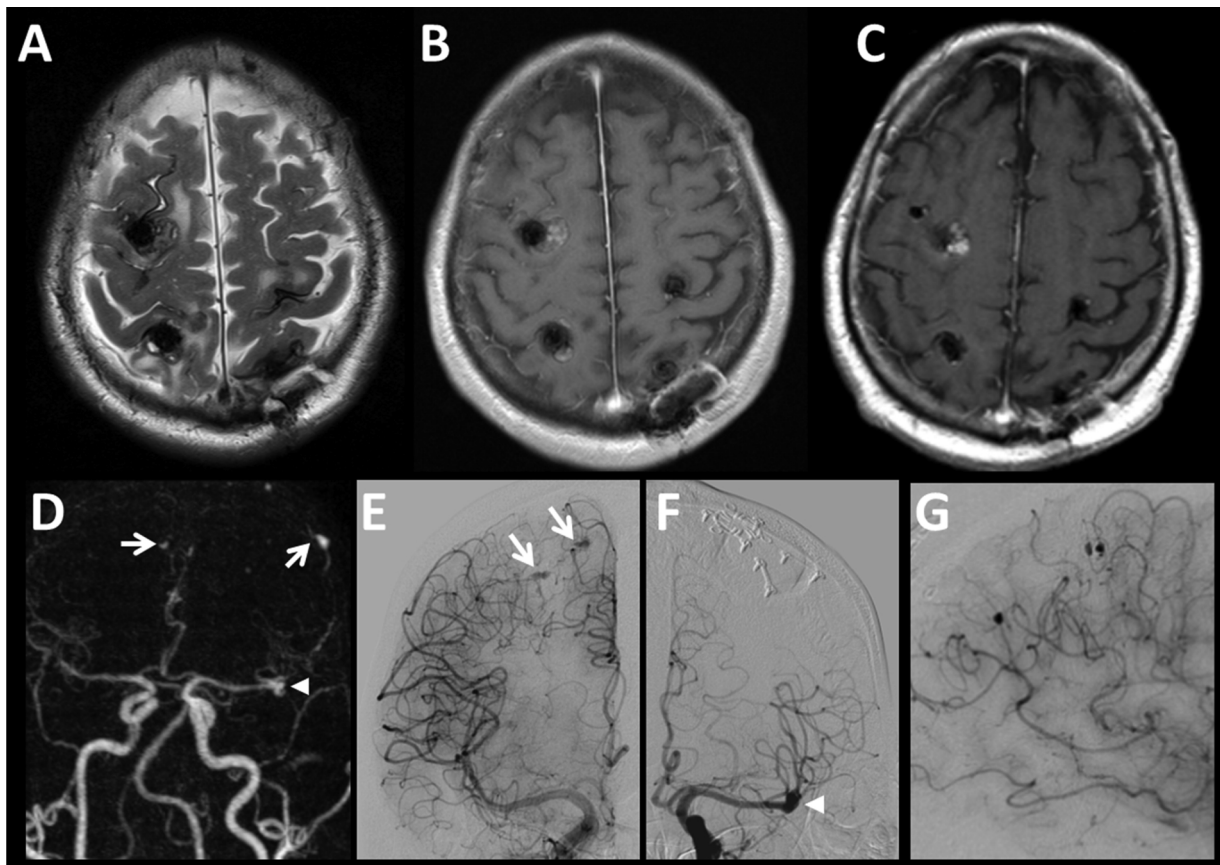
Initial MRI showing multiple hemorrhagic cerebral focal lesions in both cerebral hemispheres accompanied by perifocal edema on T2- (A), and hemorrhage of various age but no definite contrast enhancement on T1-weighted (B) MRI images. Post-contrast MRI (C) after radiotherapy and 3 months after diagnosis revealed beginning regression of the lesions. Contrast enhanced MR-angiography (D) documented an ectatic M2-segment of the left MCA (arrowhead) and small intra- and extracranial aneurysms (arrows). Digital subtraction angiography revealed distal neoplastic aneurysms (arrows) in the late arterial phase of the right internal carotid injection series (E) and a dysplastic ectatic M2-segment (arrowhead) in the left internal carotid injection series (F). (G) Close-up lateral view of the peripheral neoplastic aneurysms – right internal carotid injection.
